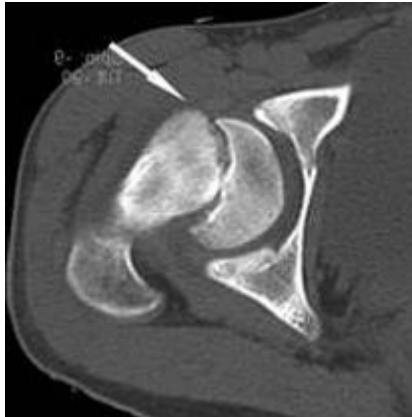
CT scan of SCFE. Form "acute on chronic". The displacement of the epiphysis of the head against the background of resorption of the dorsal part of the neck. "Step" on the ventral side of the neck.
